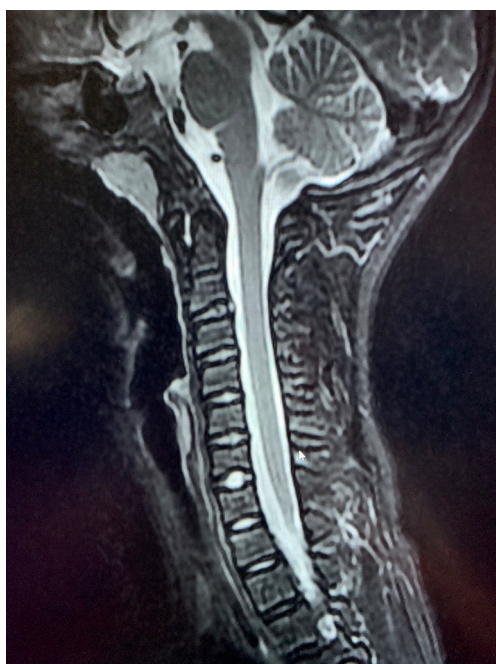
The magnetic resonance imaging of case 1 shows cervical curvature changes and mild cervical disc degeneration.
